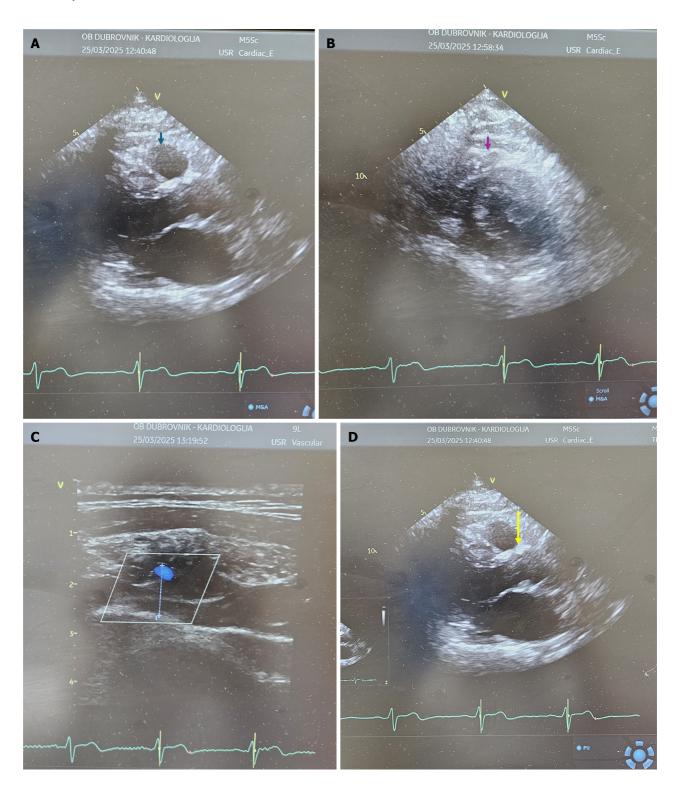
Epicardial adipose tissue thickness. A: Measured from parasternal long-axis view (blue arrow); B: Measured from parasternal short-axis view (purple arrow); C: Measured from modified three-chamber view with a linear probe (dotted line); D: Measured from parasternal long-axis view at Rindfleisch fold (yellow arrow).
